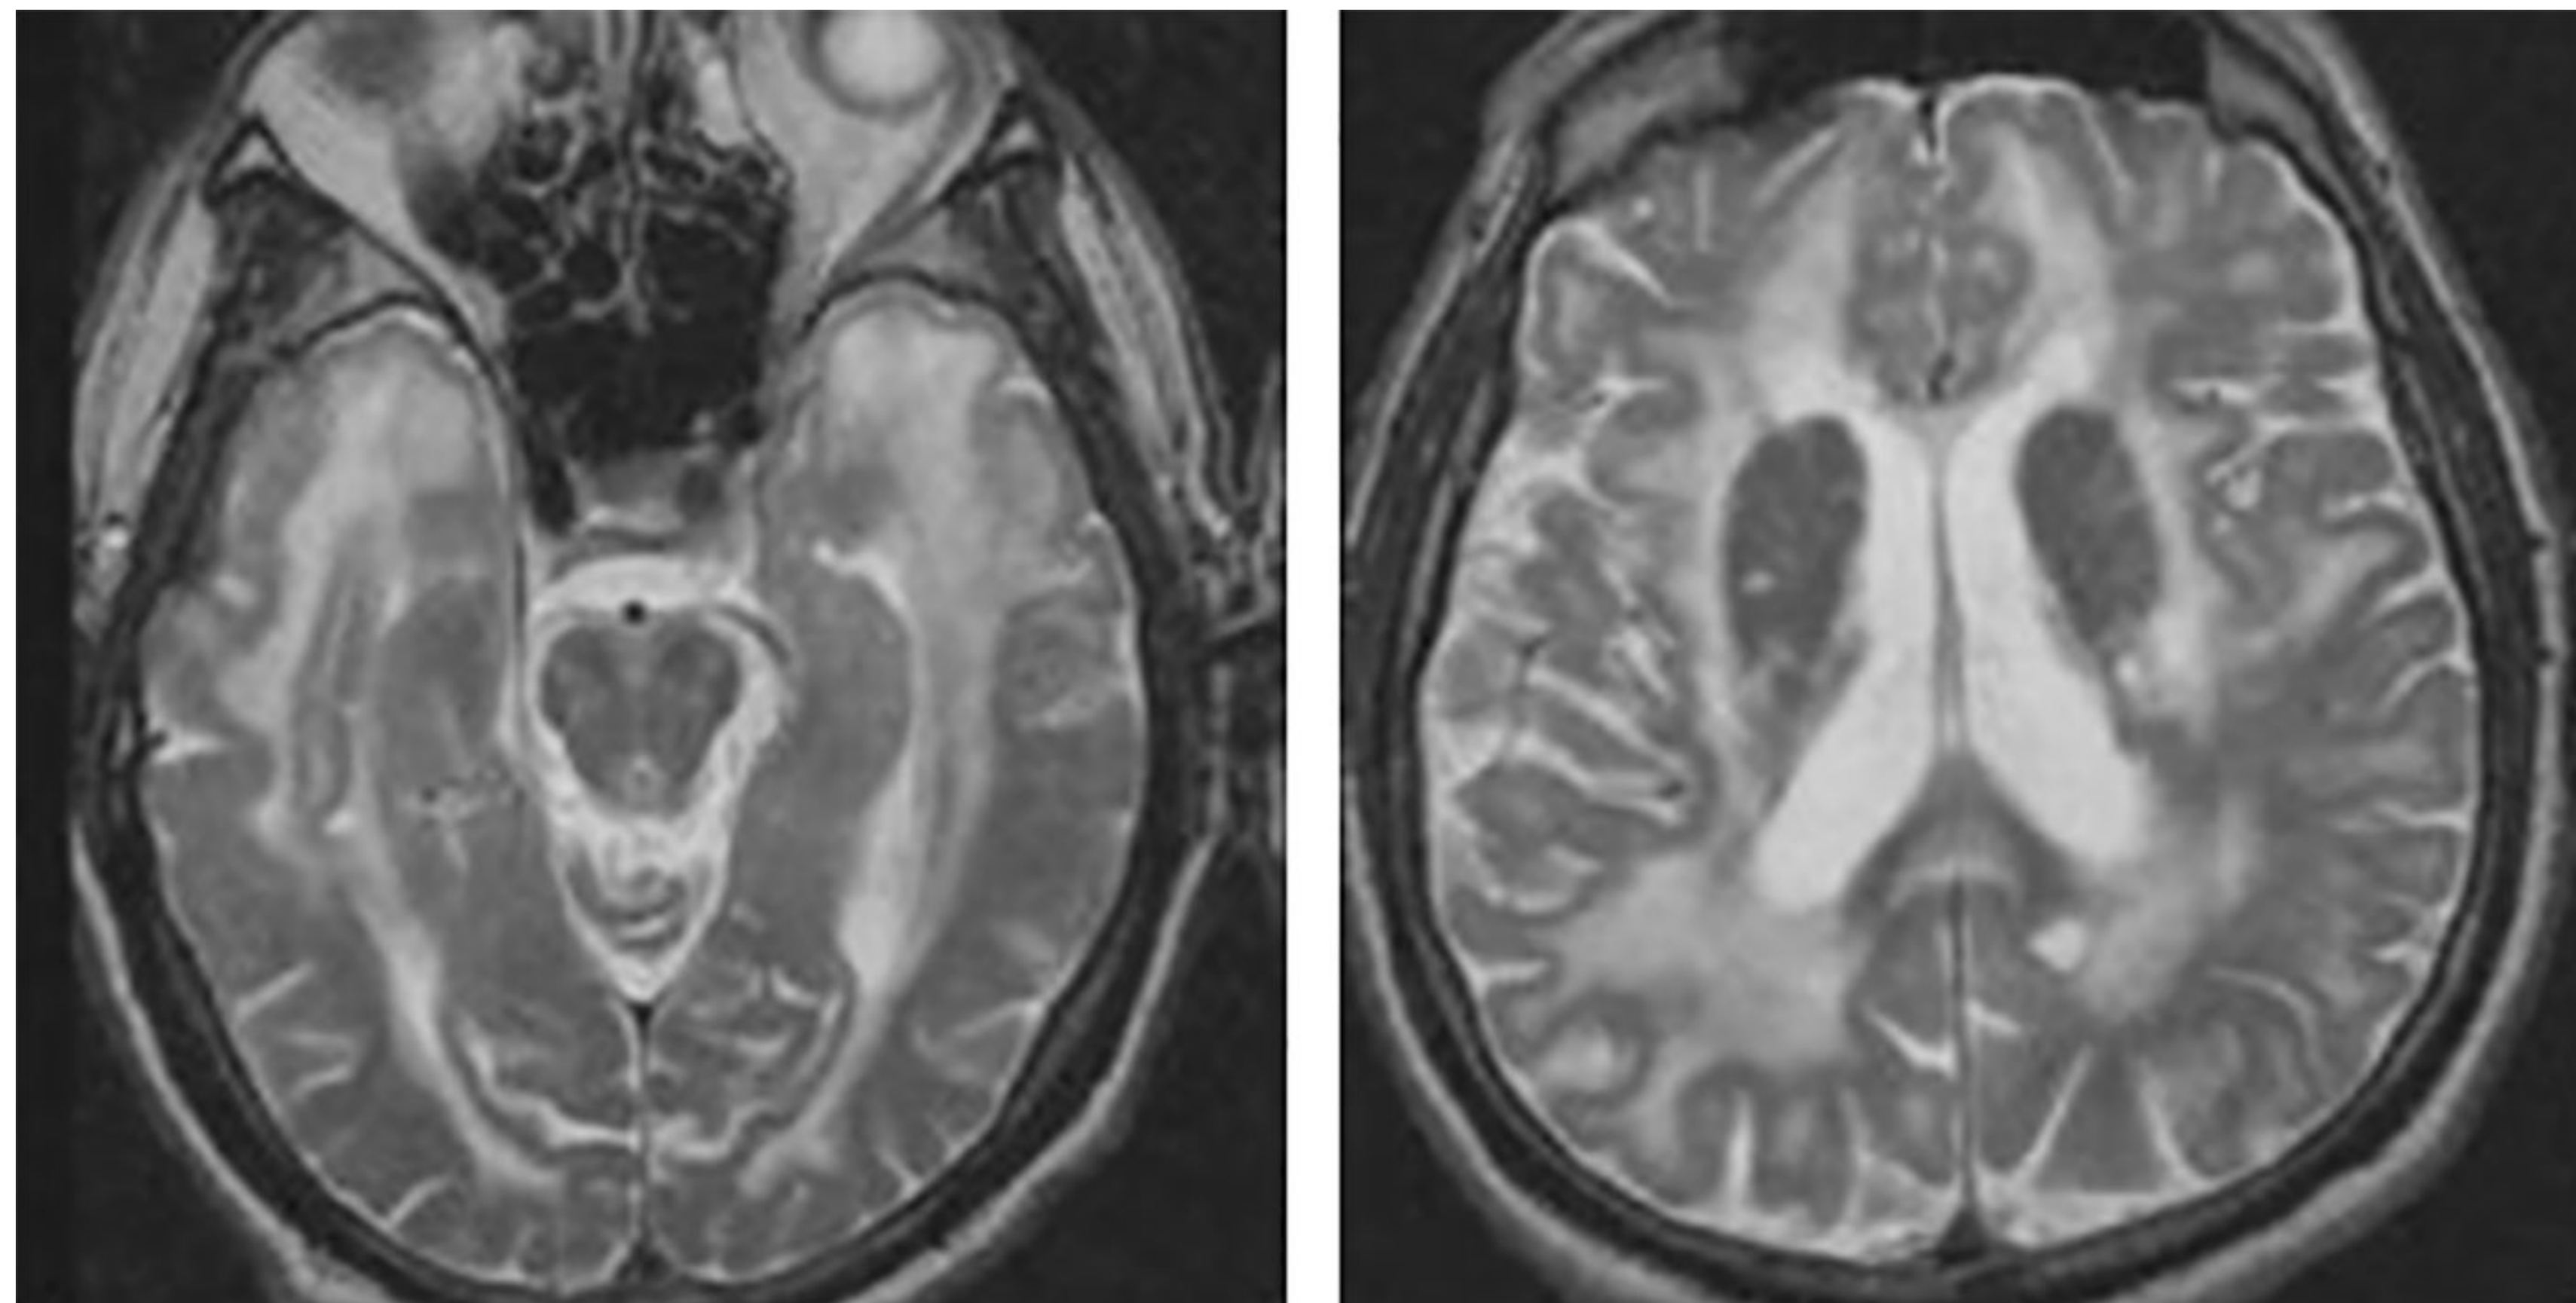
MRI of the brain reveals presence of leukoencephalopathy in the anterior temporal lobes (left) and the external capsule (right). Image obtained from Locatelli et al. 2020 (DOI: 10.3389/fpharm.2020.00321).
